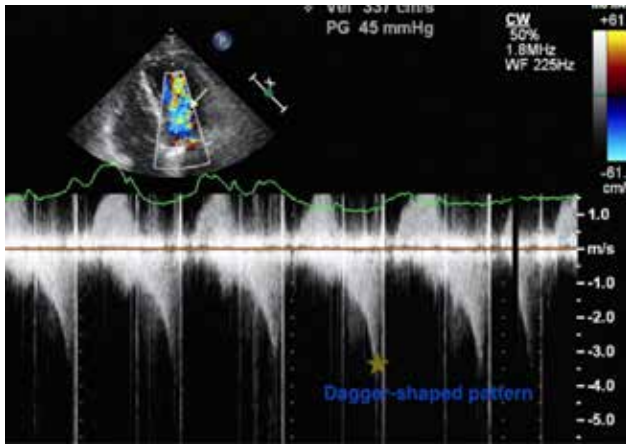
CW doppler study of LVOT shows a late peaking gradients (Dagger shaped pattern).
